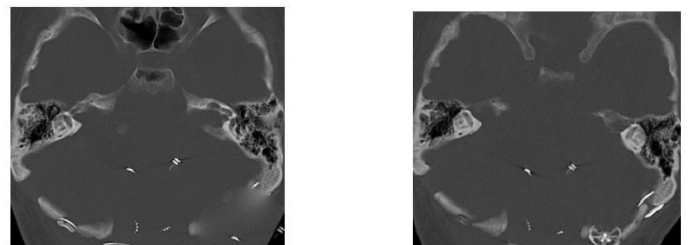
Postoperative CT scan performed on August 2, 2010 (7A) and August 25, 2010 (7B), after the second fitting session. The CT scans confirmed the correct placement of the electrode paddle on the right side but the electrode paddle displacement on the left side.
